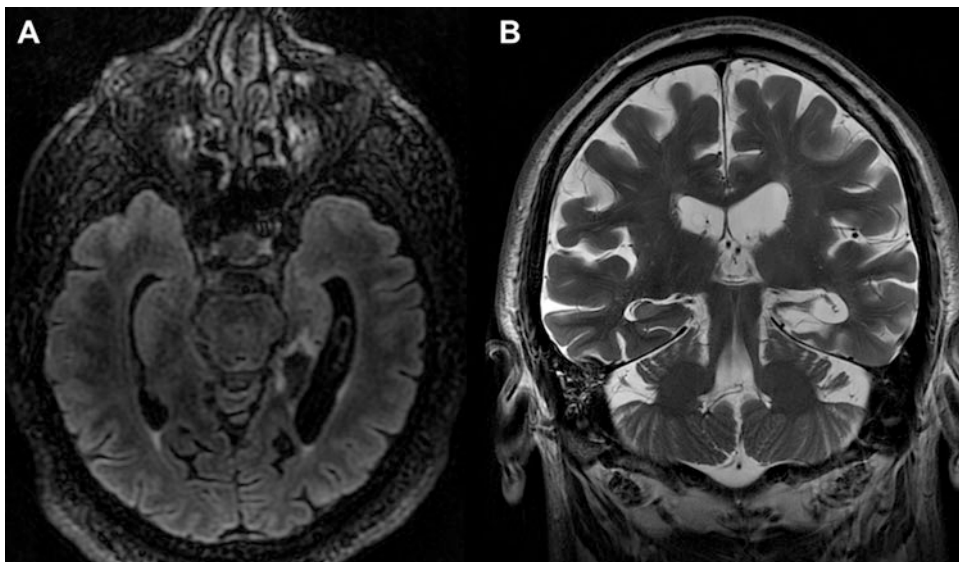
80 years old patient with strategic stroke including the left corpus of hippocampus and para-hippocampal gyrus (a, axial FLAIR; b coronal T2w)
